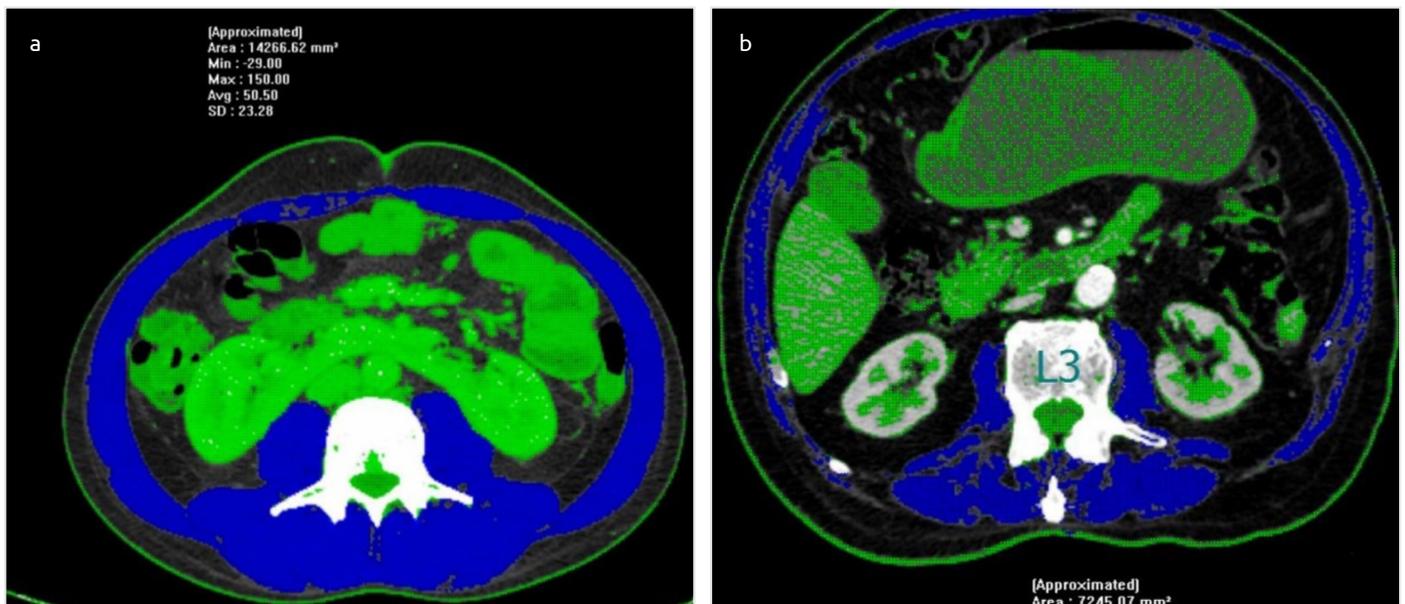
a) Non-sarcopenic patient CT image, b) Sarcopenic patient CT image
